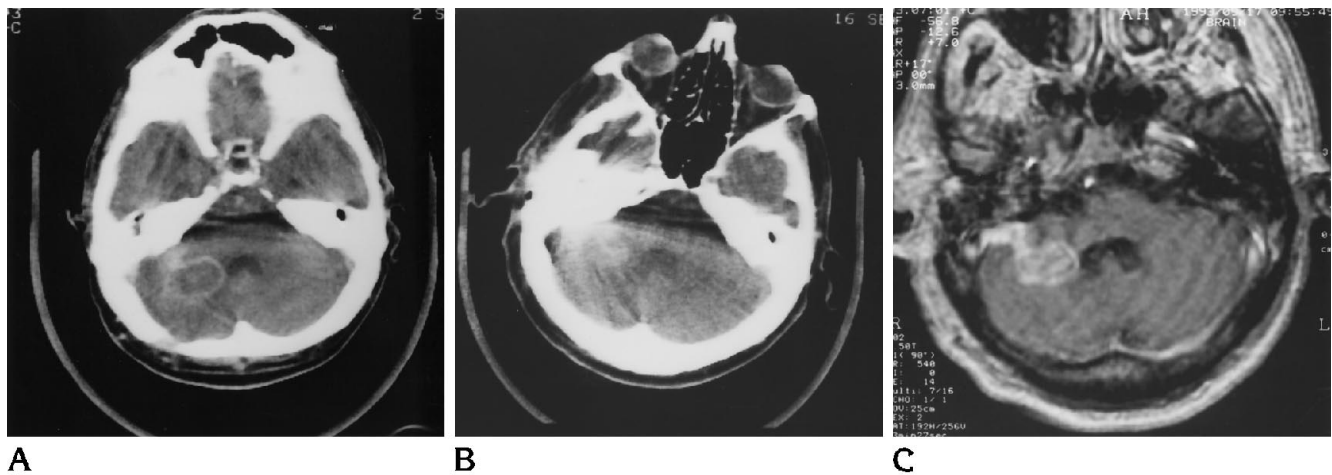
A, Case 1. Axial postcontrast CT shows a ring-enhancing mass lesion in the right cerebellar hemisphere and enhancement extending from it to the petrous surface of the hemisphere.
